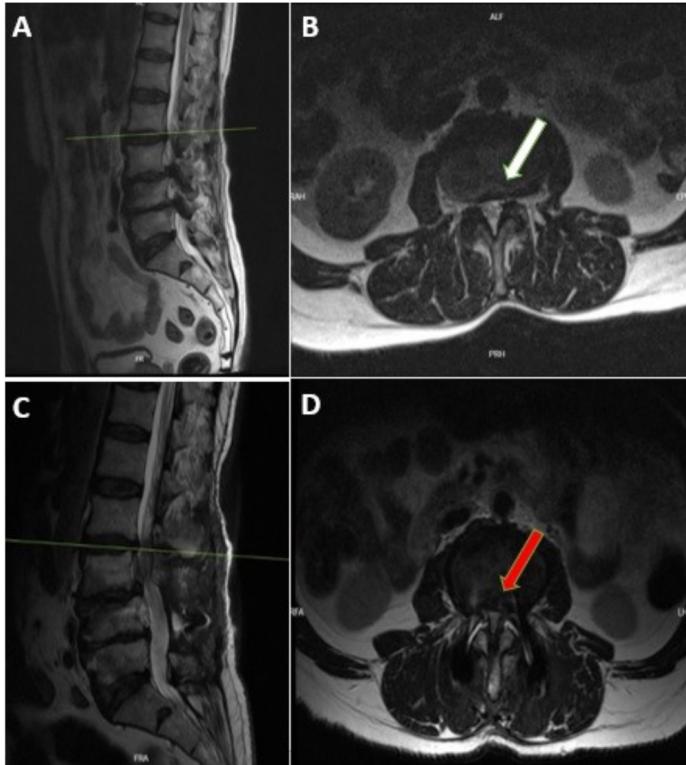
A and B, preoperative sagittal and axial lumbar T2 MRI. A 58-year-old male patient underwent lumbar decompression and fusion surgery for L3-L5 spinal stenosis. C and D, postoperative sagittal and axial lumbar T2 MRI. A rigid rod was used during the operation. Lumbar MR imaging performed at the postoperative 15th month revealed adjacent segment disease at the L2-L3 level. The patient was reoperated. White arrow: Canal diameter at L2-L3 level in the preoperative period. Red arrow: Canal diameter at L2-L3 level in the postoperative period.
